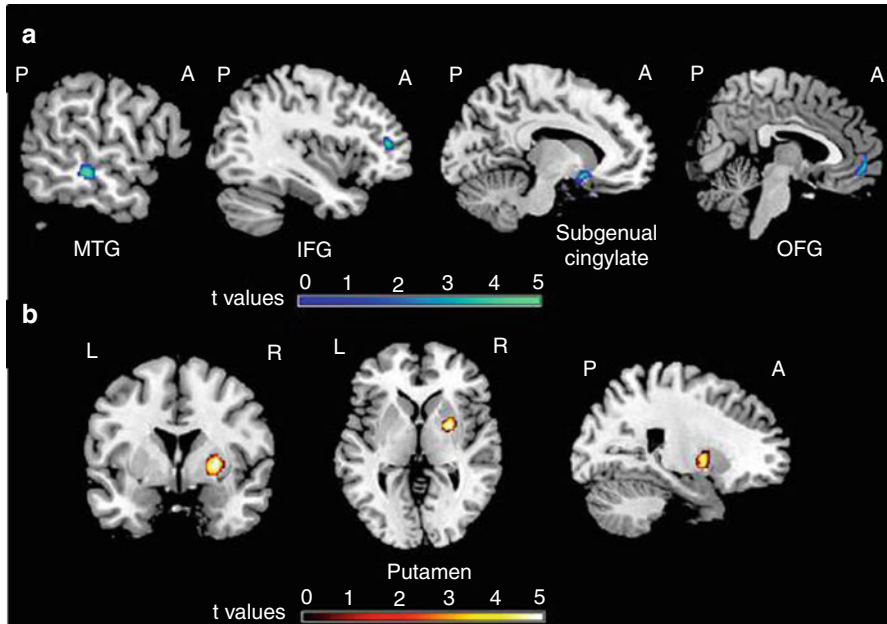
Differences of regional gray matter (GM) volume between pediatric patients with migraine and healthy controls: (a) compared to healthy controls, pediatric patients had reduced GM volume of the left middle temporal gyrus (*MTG*), inferior frontal gyrus (*IFG*), subgenual cingulum, and right orbitofrontal gyrus (*OFG*) (*blue-green* scale according to *t* values); (b) compared to controls, pediatric patients had an increased GM volume of the right putamen (*red-yellow* scale according to *t* values). The GM differences have been superimposed on a high-resolution T1-weighted template (neurological convention) (Reproduced with permission from Rocca et al. [15])
